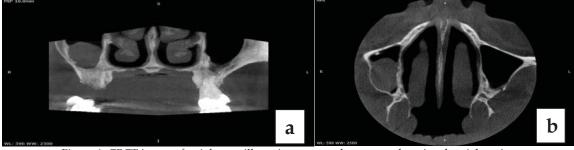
CBCT image of a right maxillary sinus mucocele: a-coronal section, b-axial section
